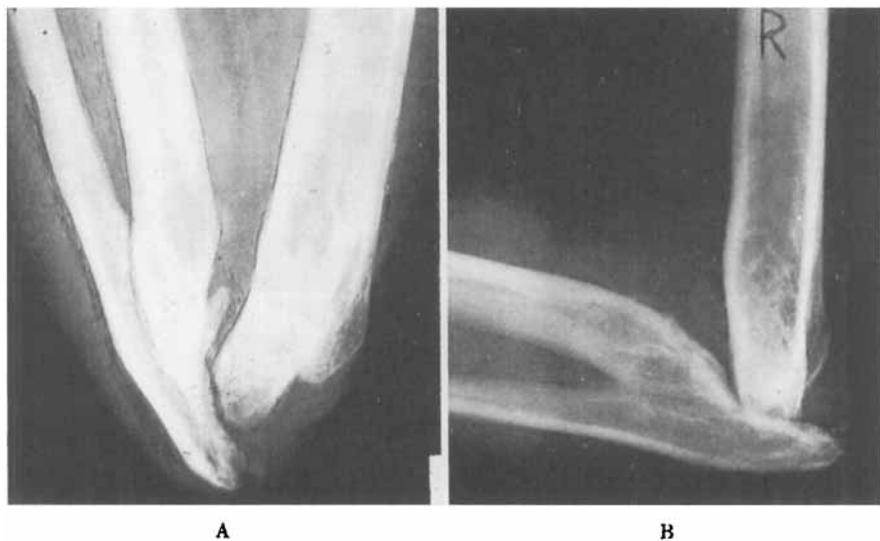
Roentgenogram of the right elbow in maximal flexion after the last operation at the age of eight years. The elbow was operated on the first time at the age of 4½ months.
